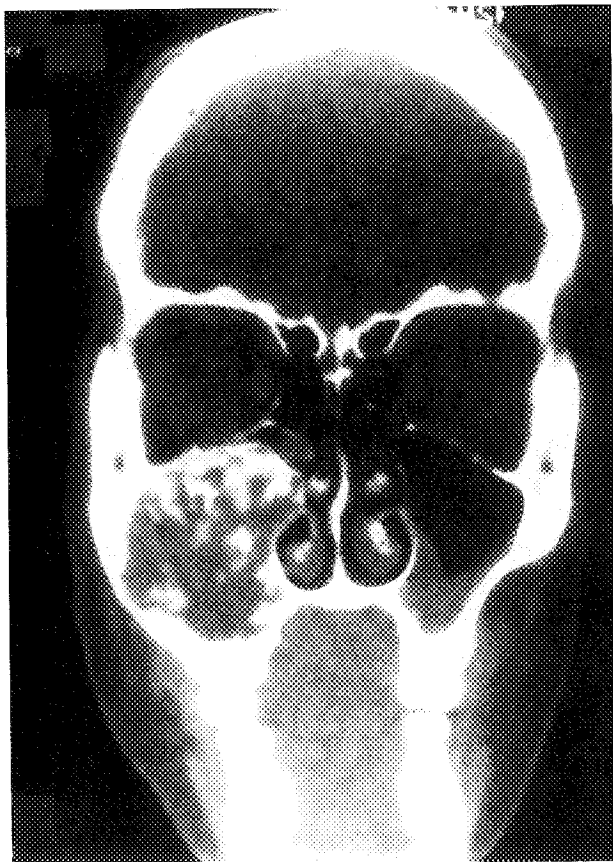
Computed tomographic scan of a large ossifying fibroma of the maxilla and maxillary sinus in a 10-year-old white girl.
